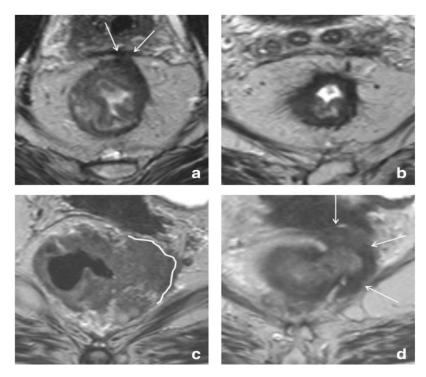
Axial MR images of two different patients showing the change in tumor size post neoadjuvant chemoradiation[8]
